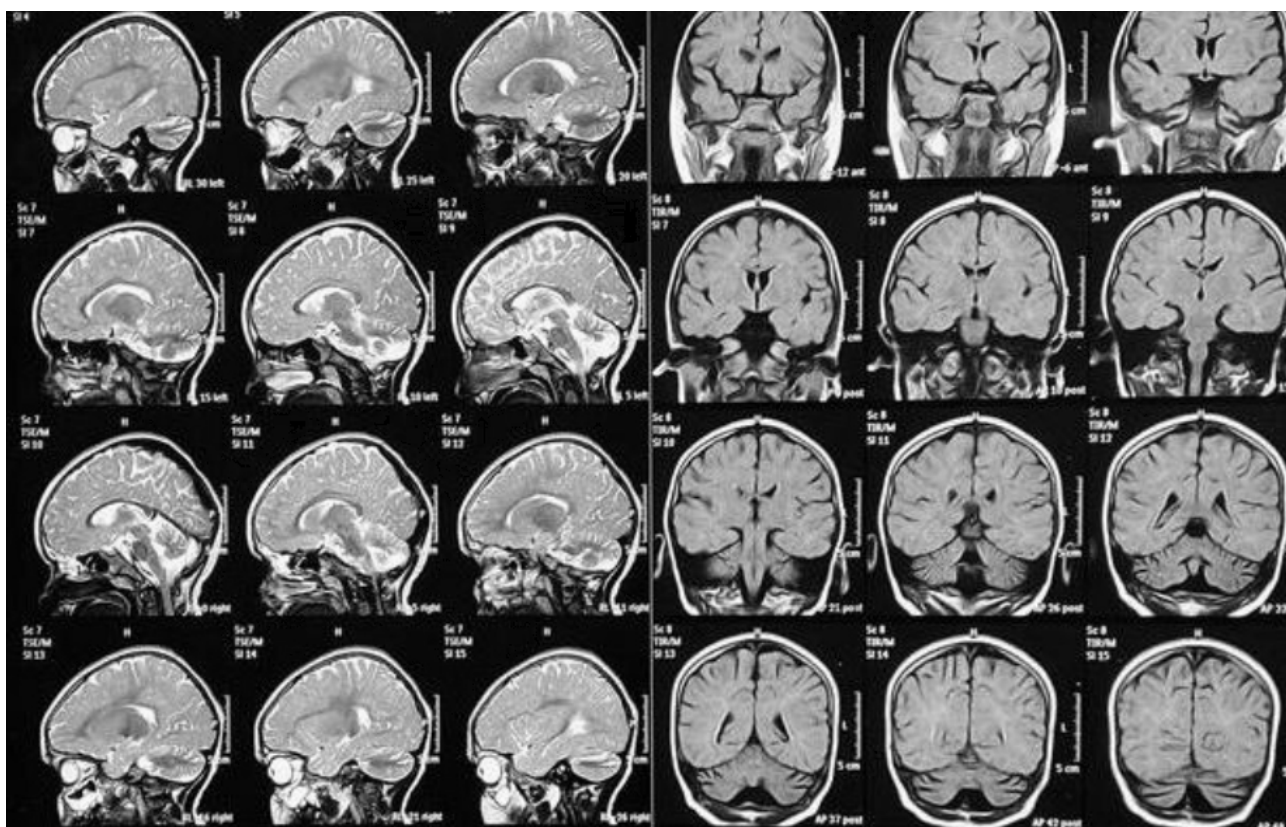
MRI brain (sagittal and coronal views) showed a cerebellar vermis and cerebellar hemisphere atrophy. MRI, magnetic resonance imaging.
